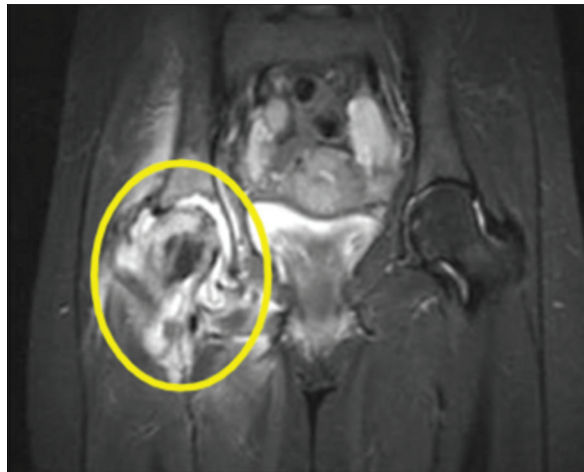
Magnetic resonance imaging pelvis short-T1 inversion recovery coronal view showing right femoral head (yellow circle) with hyperintensities within (oedema) and adjacent soft-tissue oedema with joint effusion. Hyperintensities also noted in the right acetabulum features suggesting tubercular aetiology
